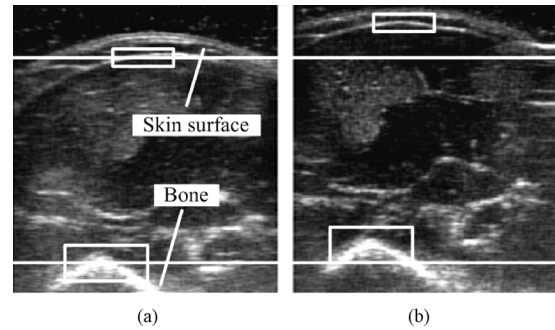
Motion tracking for the ultrasound images using a two-dimensional cross-correlation algorithm. (a) The image taken at the moment before contraction and (b) the image taken when the torque reached MVC. Two rectangular ROIs were selected on the upper and lower boundaries of the cross-sectional image of biceps brachii, respectively.
